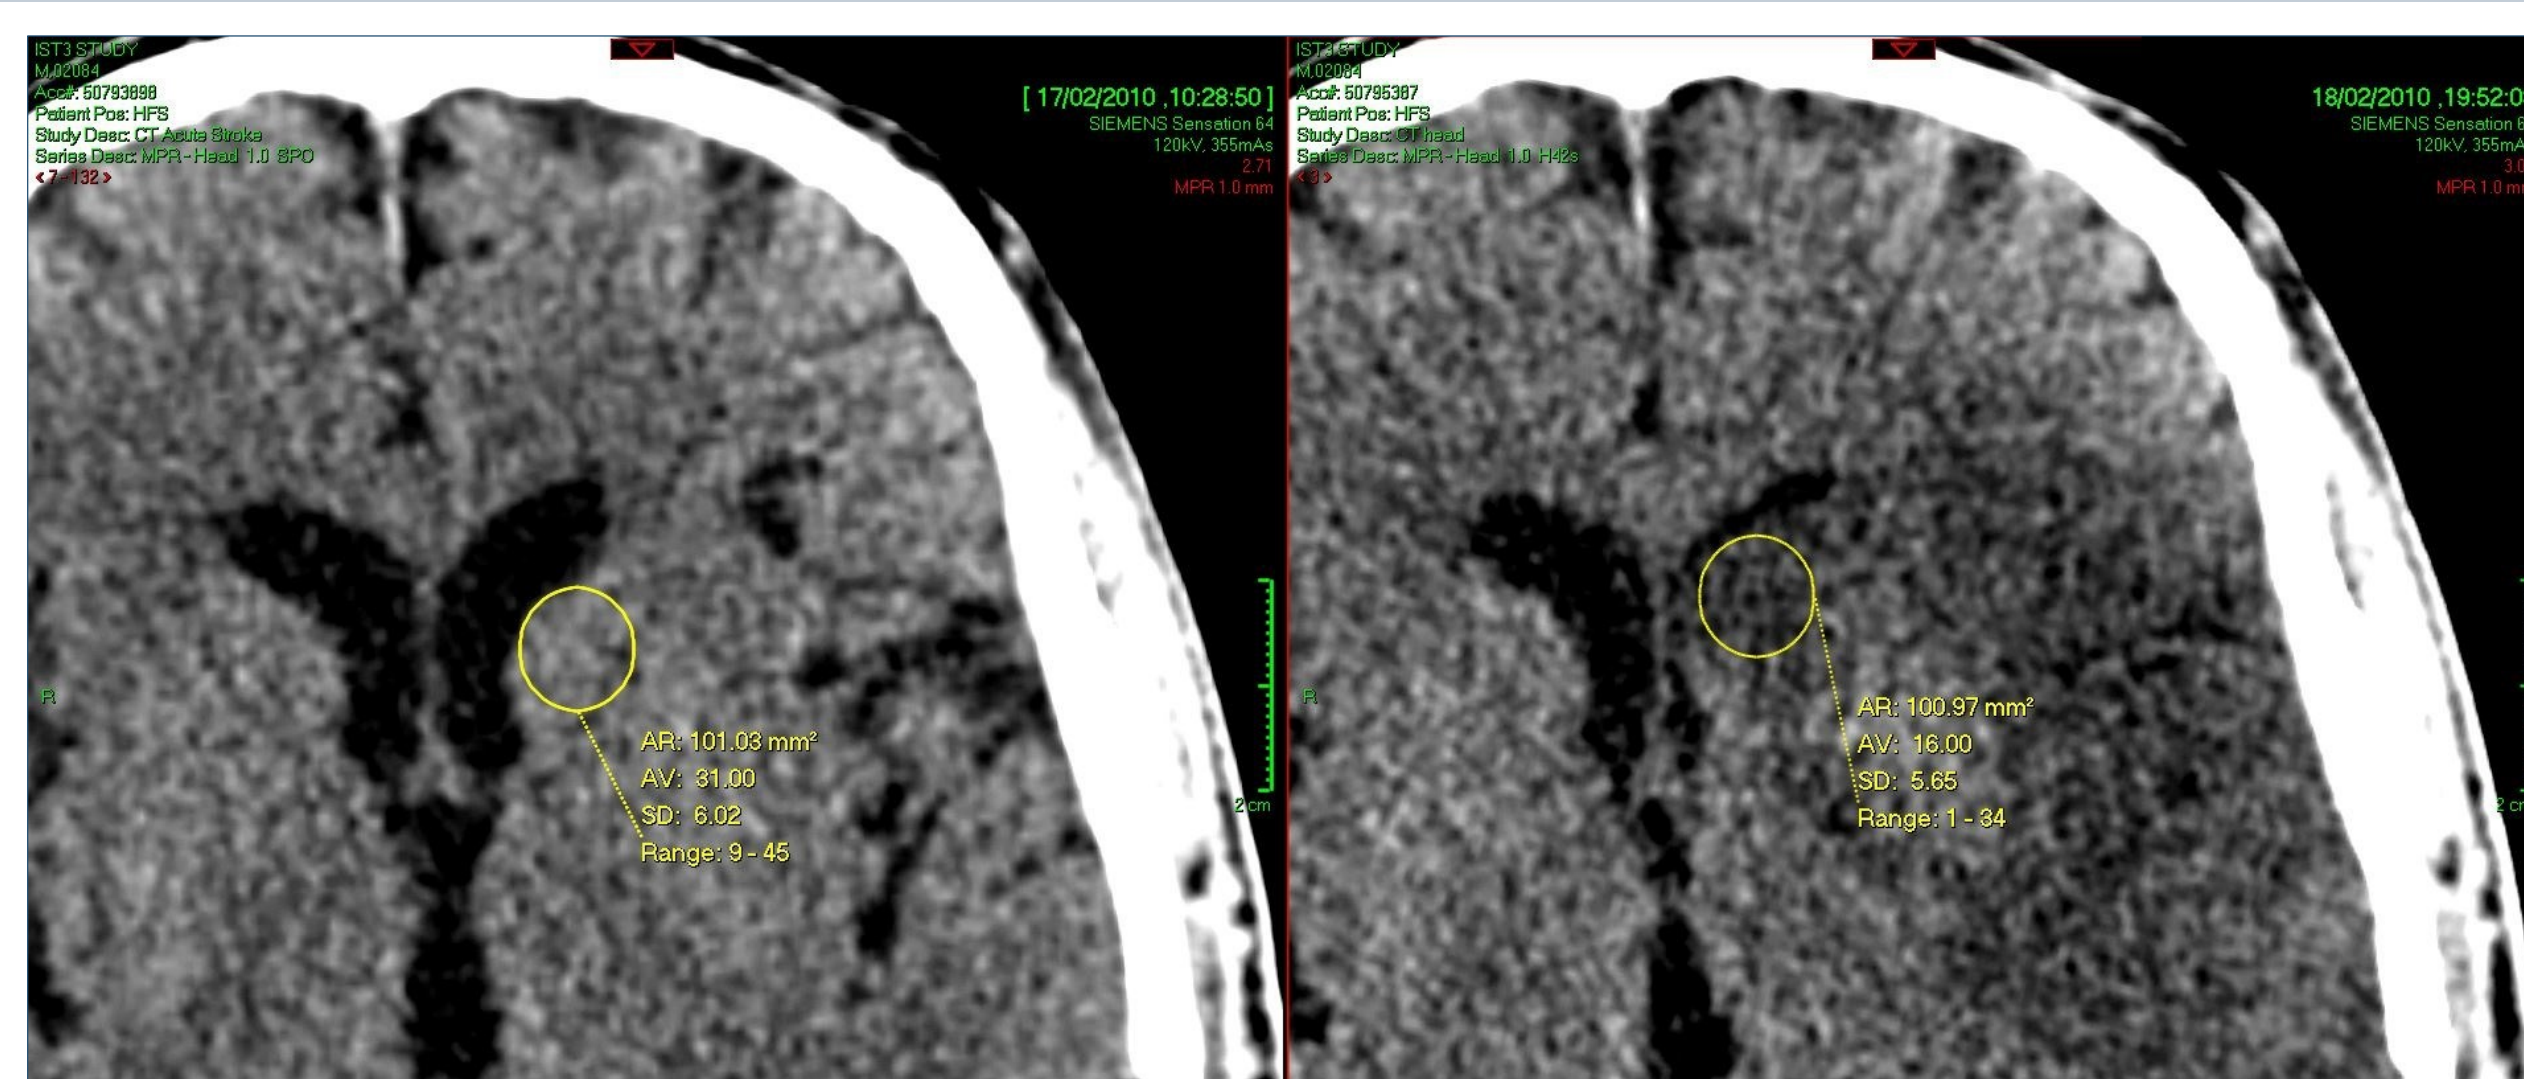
ROI placement within infarct on baseline (left) and follow-up (right) thin-slice CT scans.
